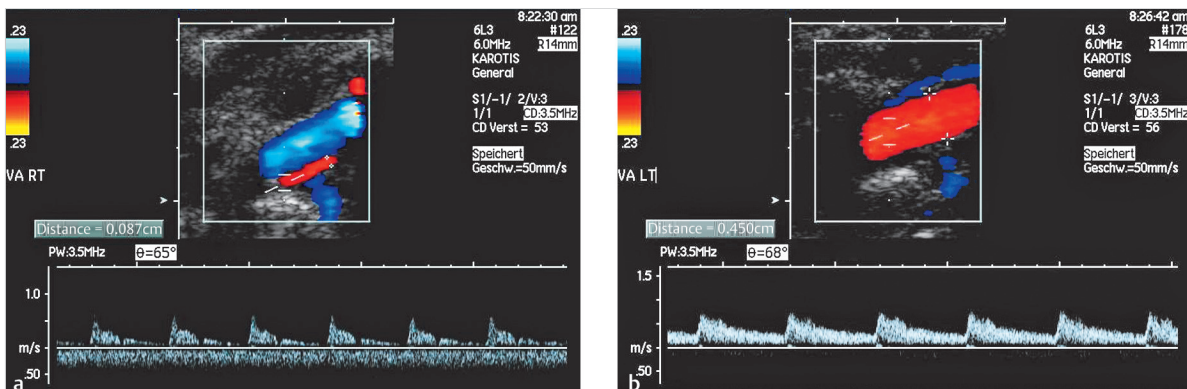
Vertebral artery hypoplasia. (a) Narrow caliber with a luminal diameter less than 2 mm (measured in multiple segments). Spectral Doppler shows a reduced flow velocity and increased pulsatility. (b) Contralateral hyperplasia with a luminal diameter of 4.5 mm.
